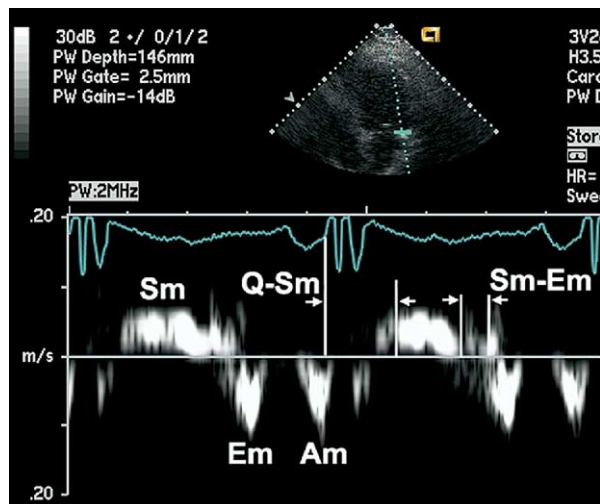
Doppler tissue imaging at lateral mitral annulus. Q wave to onset of systolic mitral annular velocity (*Sm*) represents electromechanical delay to onset of contraction. Time interval from end of Sm to onset of early diastolic mitral annular velocity (*Em*) is time from end of contraction to onset of relaxation. *Am*, Late diastolic mitral annular velocity at time of atrial contraction.
